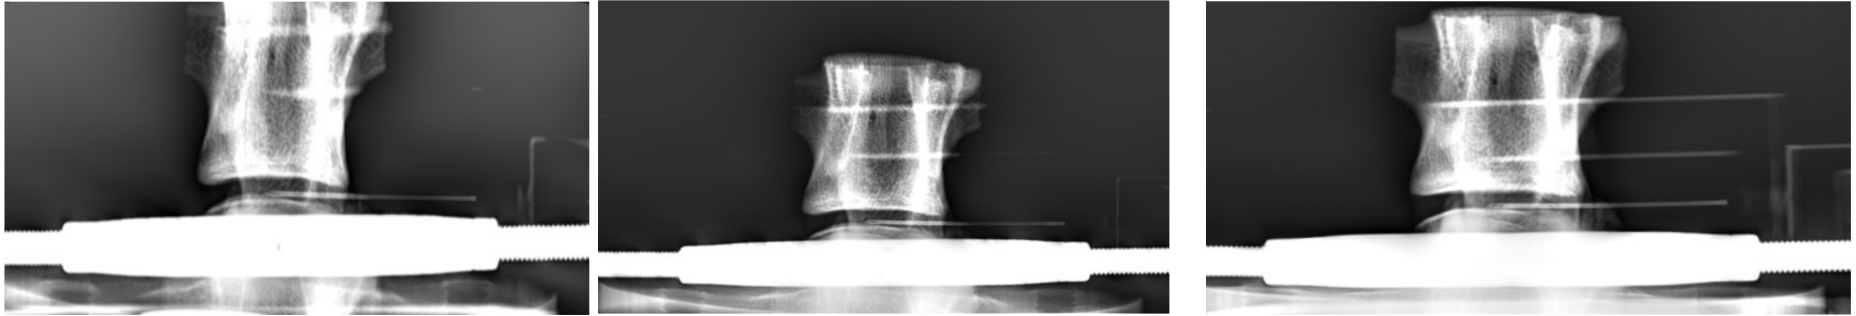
Anterolateral view radiographs displaying three repeated needle insertions for one FSU.
